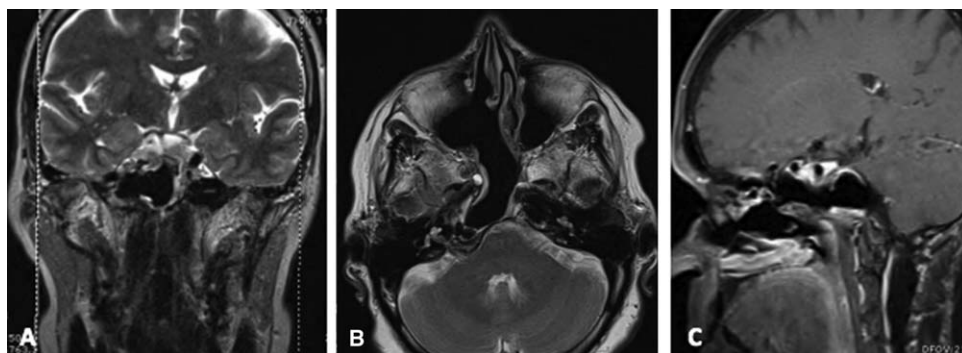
Postoperative MRI performed 3 years after surgery showing a well-healed and aerated surgical cavity in the coronal T2-weighted (A), axial T2-weighted (B) and sagittal T1-with gadolinium (C) planes.
